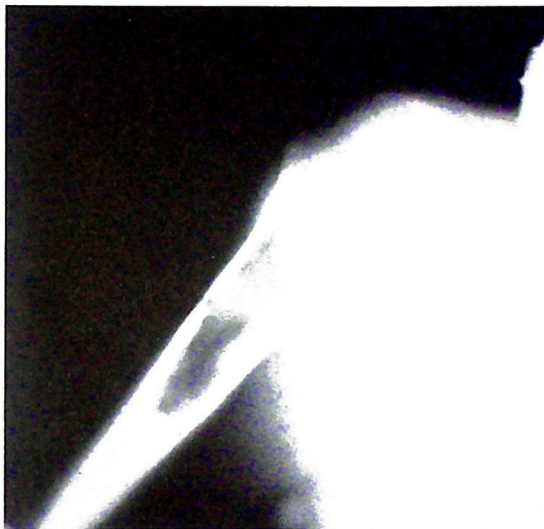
Radiograph of the right humerus showing a lytic lesion in a patient with solitary plasmacytoma of bone. This patient later developed generalized multiple myeloma.
